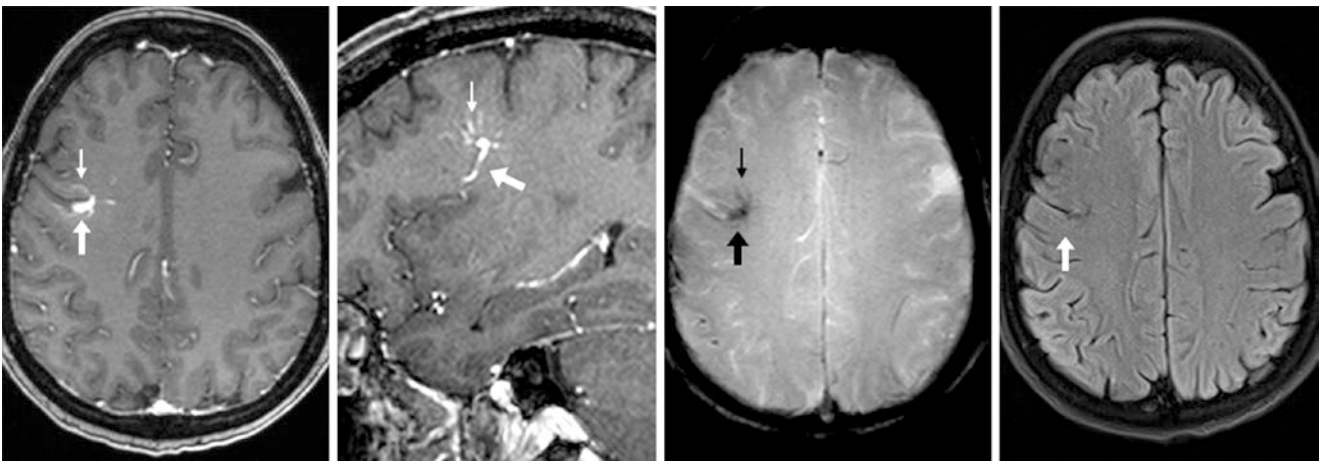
A 59 year old with an acute speech deficit underwent a 3T MRI with postcontrast axial (*left*) and sagittal (*left middle*) GE T1WIs that delineated a moderate-sized draining vein (*arrows*) from a DVA
